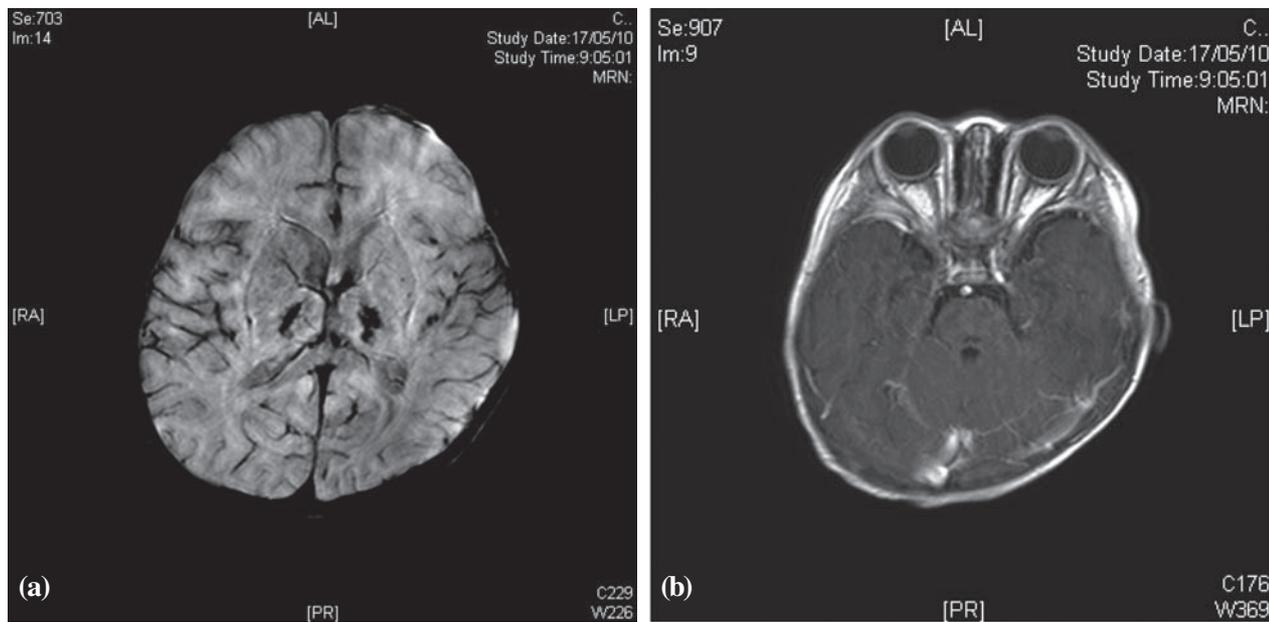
(a) MRI performed on day 42: Susceptibility artefacts on susceptibility-weighted sequence suggest presence of subacute haematomata or early microcalcification at the thalami. (b) Post-contrast T1-weighted image showed non-enhancing hypointense foci at the posterior pons, corresponding areas appear hyperintense on T2-weighted images and hypointense on FLAIR sequence, compatible with cystic changes.
